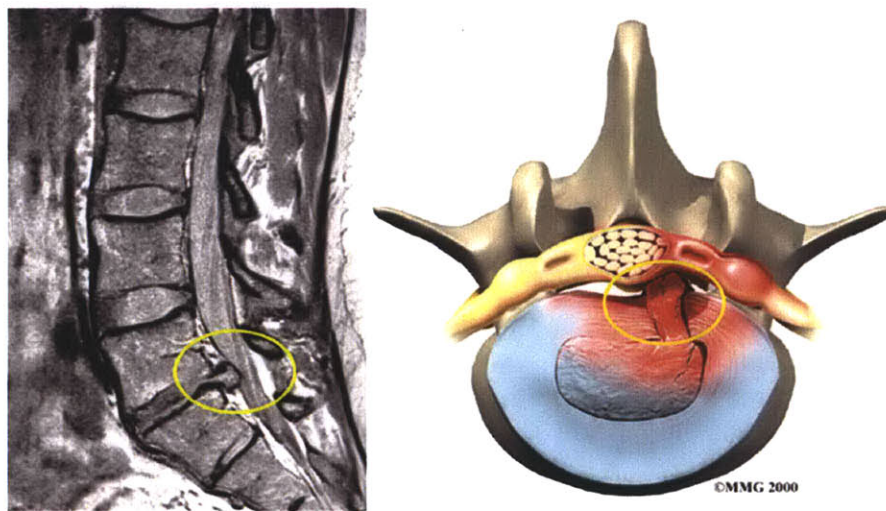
Example of a herniated disc on MRI and in a sketch
